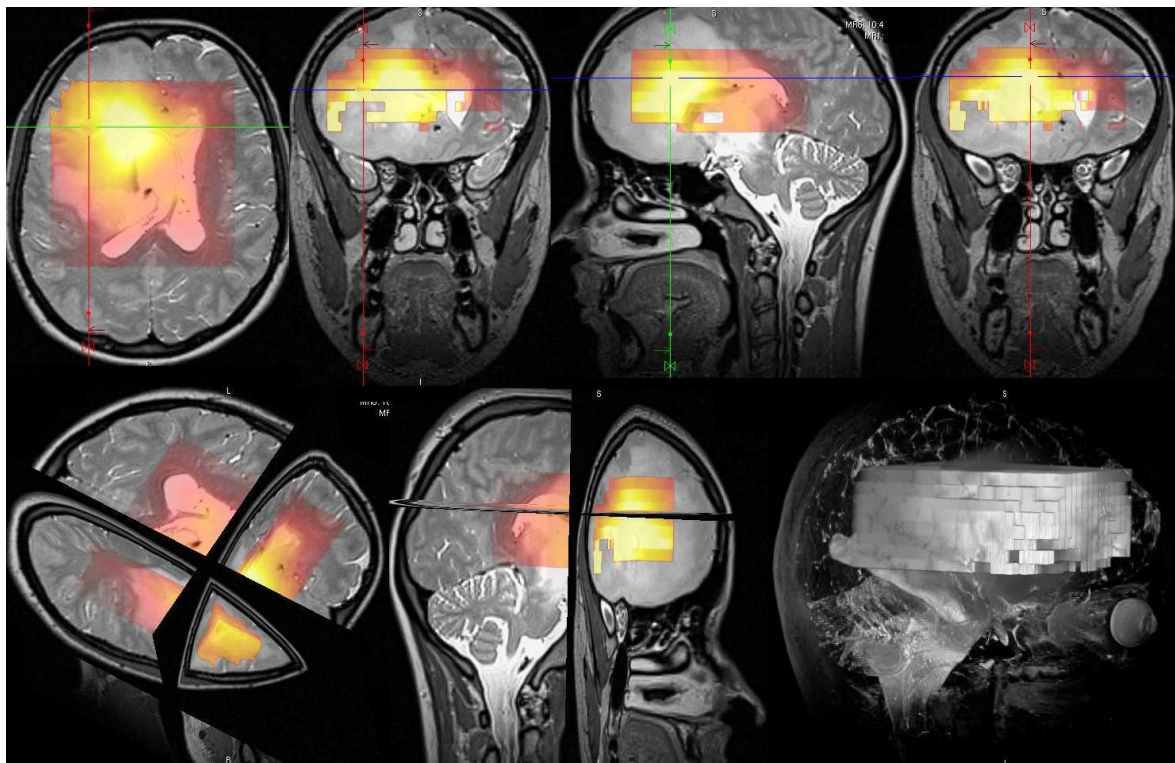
The example of 3D MR images merged with 3D metabolic map (N-acetylaspartate) in a navigated system used for a stereotactic biopsy.
